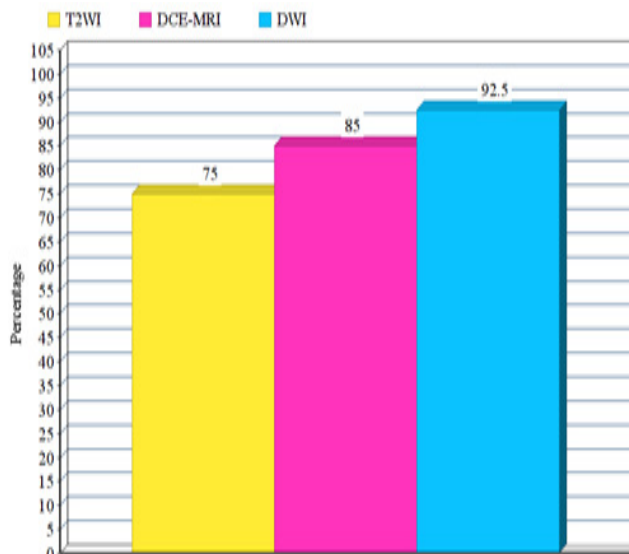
Overall staging accuracy of T2WIs, DCE-MR & DWI in staging of uterine carcinoma.
